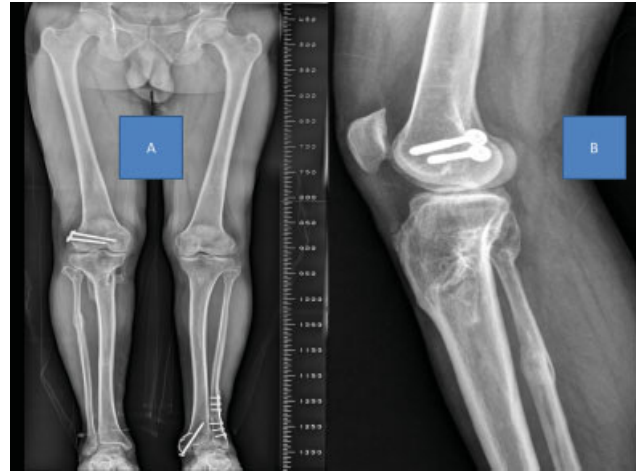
and 4B Anteroposterior and lateral radiographs of Patient 9 with 12 months of follow-up.
